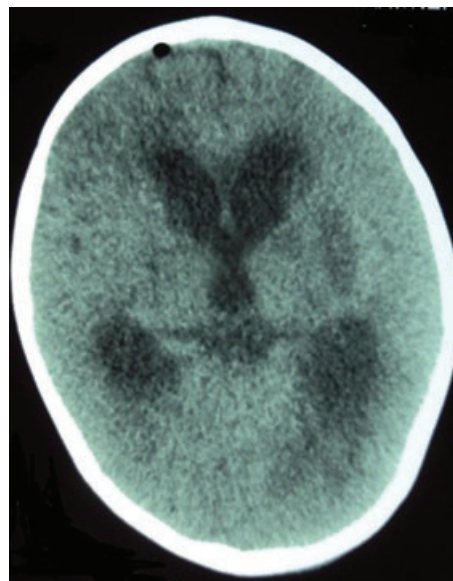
Non-contrast computed tomography image of head with dilated lateral and third ventricles, suggestive of obstructive hydrocephalus.
